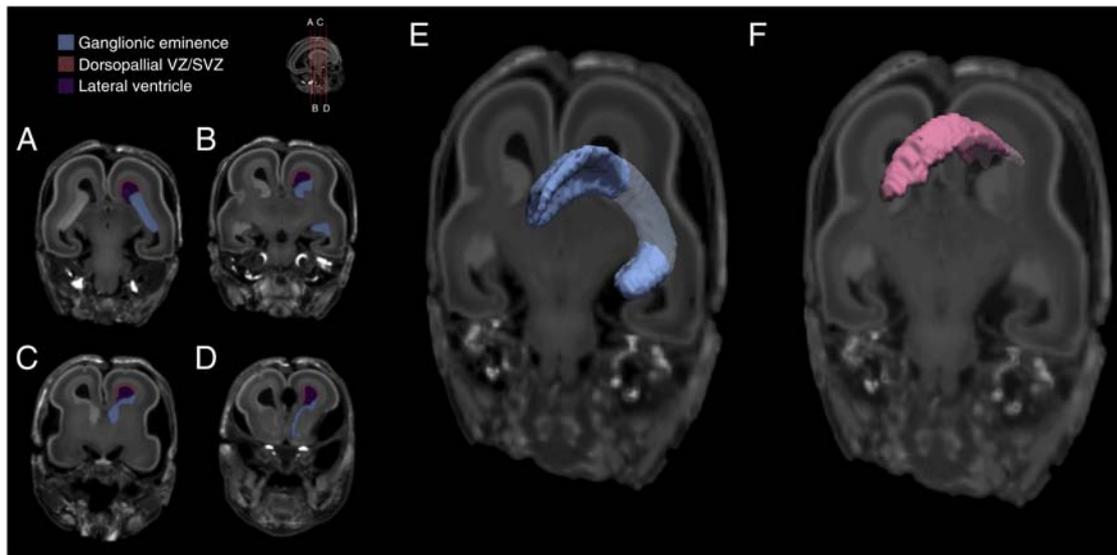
Structural MRI overview of the anatomical structures of interest: subpallial ganglionic eminence and dorsopallial ventricular zone. Structural sequences acquired at $\alpha = 40^\circ$ provide optimal contrast to define anatomical structures of interest. Ganglionic eminence (blue) was masked in its entirety, from hippocampus, in an arc along the lateral border of the lateral ventricle (A–C) to the anterior extremity of the anterior horn of the lateral ventricle (D). The anatomical masks of ganglionic eminence used in further analysis excluded the extension of the rostral migratory stream (E). Dorsopallial ventricular zone/subventricular zone (pink) was masked caudally from the level of the posterior extremity of ganglionic eminence and rostrally to the anterior extremity of the anterior horn of the lateral ventricle (A–D, F). The occipital and temporal components of VZ/SVZ are not easily demarcated anatomically, and were excluded from this study, which focused principally on frontal lobe development. VZ: ventricular zone; SVZ: subventricular zone.
